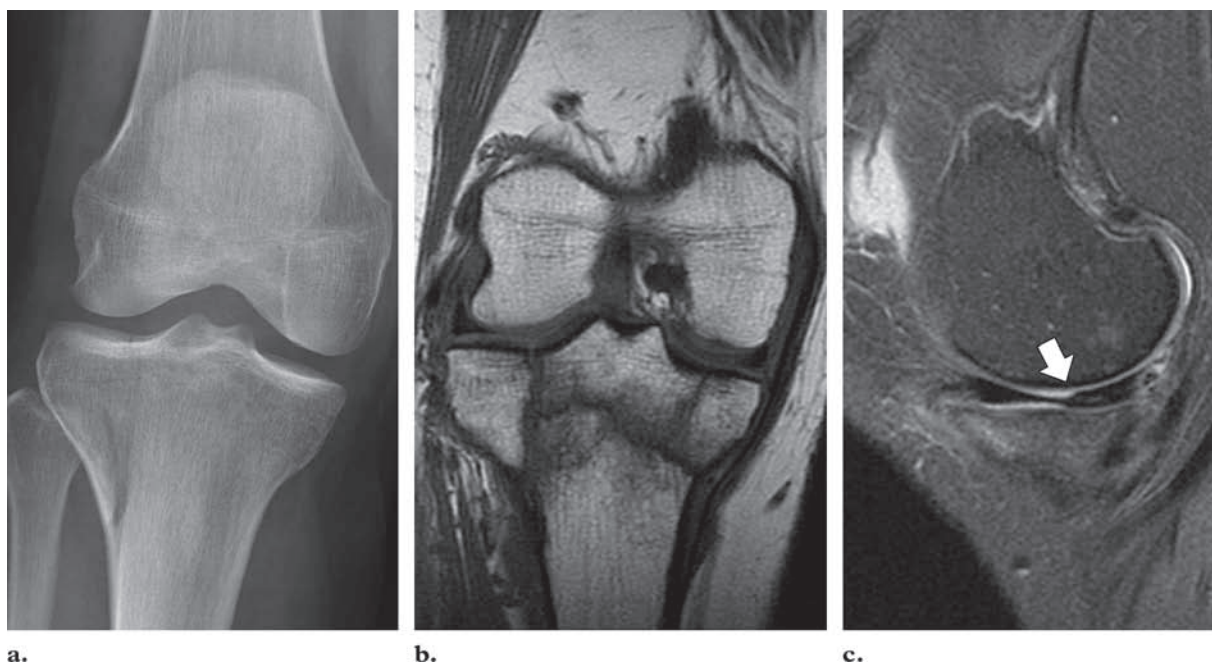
Four-part fracture in a 41-year-old woman who was involved in an altercation. (a) Plain radiograph shows a split fracture of the lateral tibial plateau. Initially, the fracture was treated conservatively with absence of weight bearing. MR imaging was performed because of continued pain and swelling and clinical suspicion of a meniscal or ligamentous injury. (b) Coronal proton-density-weighted MR image shows an unsuspected nondepressed four-part fracture of the tibial plateau. (c) Sagittal T2-weighted MR image shows contour irregularity and abnormal high signal intensity of the medial meniscus (arrow), findings compatible with a tear.
